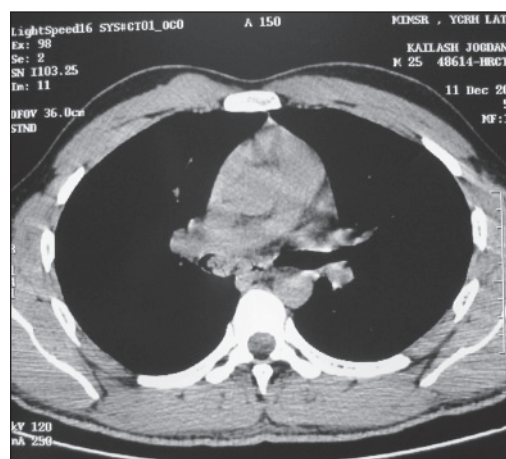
CT thorax Mediastinal window- showing lobulated growth blocking Right main Bronchus slit like patent opening without mediastinal lymphadenopathy
